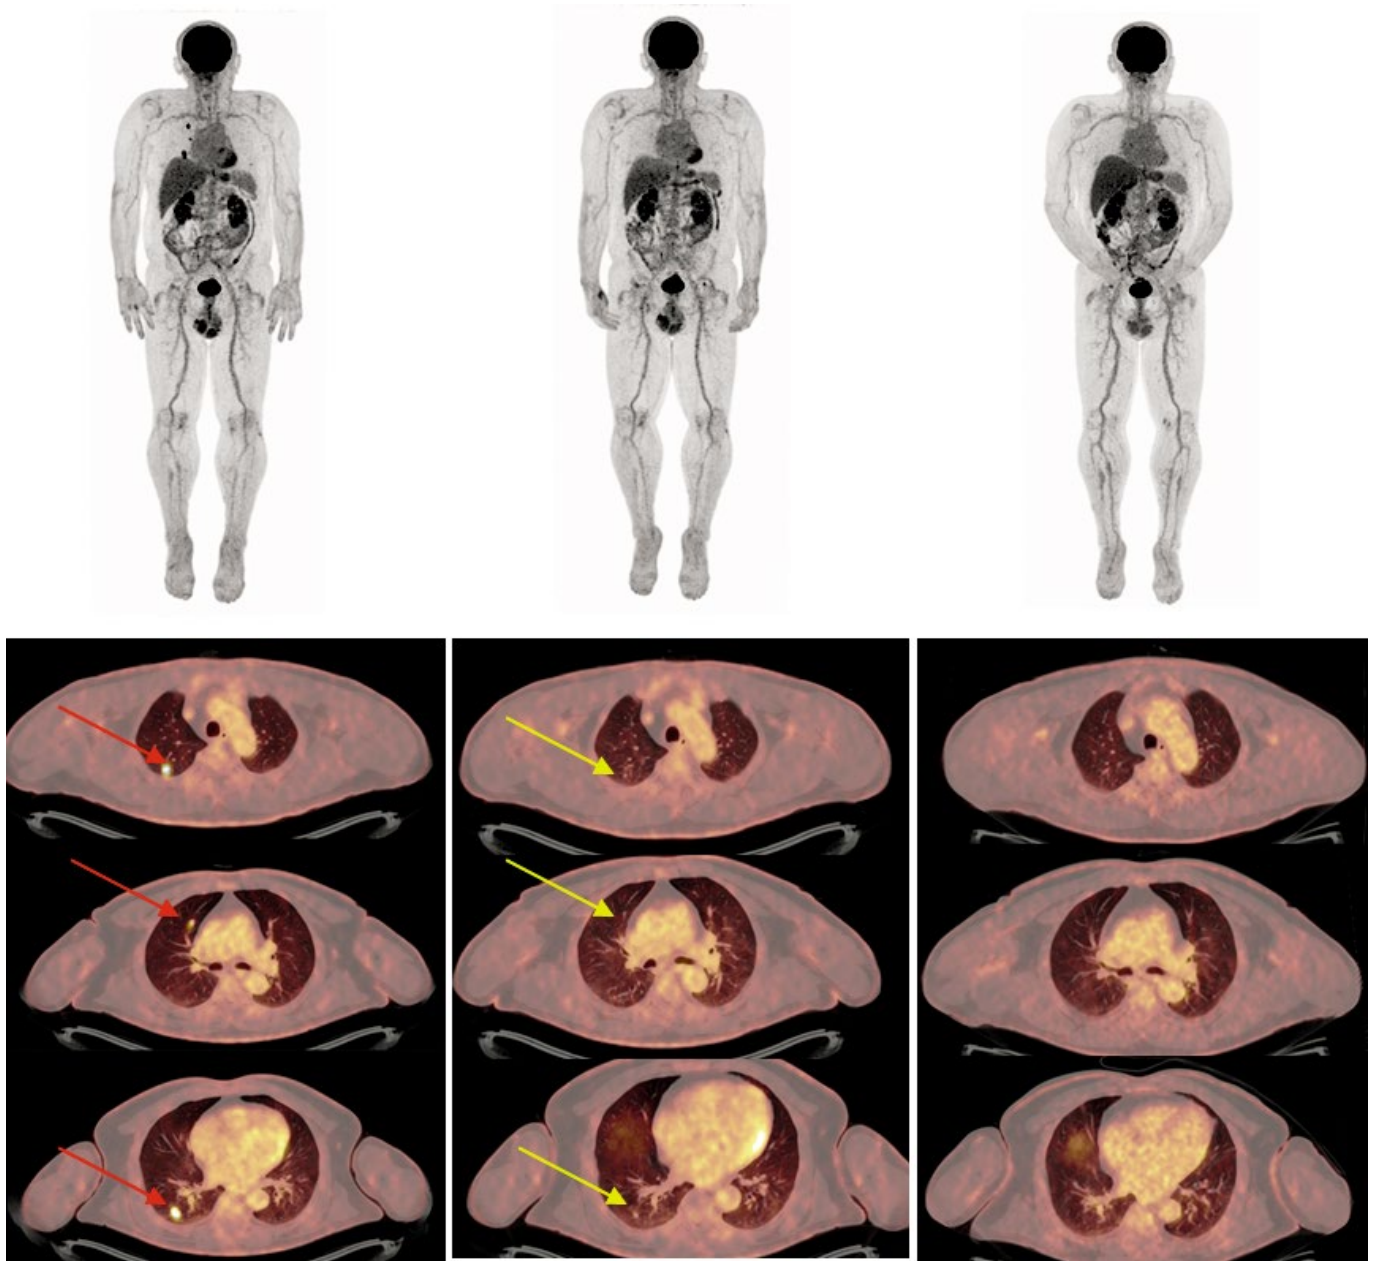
A 67-year-old male patient, diagnosed with metastatic NRAS-mutated cutaneous melanoma with lung metastases in January 2021, was treated with pembrolizumab in the first-line setting. Serial ¹⁸F-FDG PET/CT scans were obtained per the study protocol. The images above show the maximal intensity projection (MIP) on the baseline PET/CT (left), on the week 4 evaluation PET/CT (middle) and at the endpoint of the study (right). The images below show transverse sections of the lungs in different planes, revealing three FDG-avid metastatic nodules in the right lung (lower left images, red arrows), only small nodules with no FDG uptake on week 4 PET/CT (lower middle images, yellow arrows), a complete metabolic response, and no residual nodules found at the end point of the PET/CT images with persistent complete remission (lower right images).
